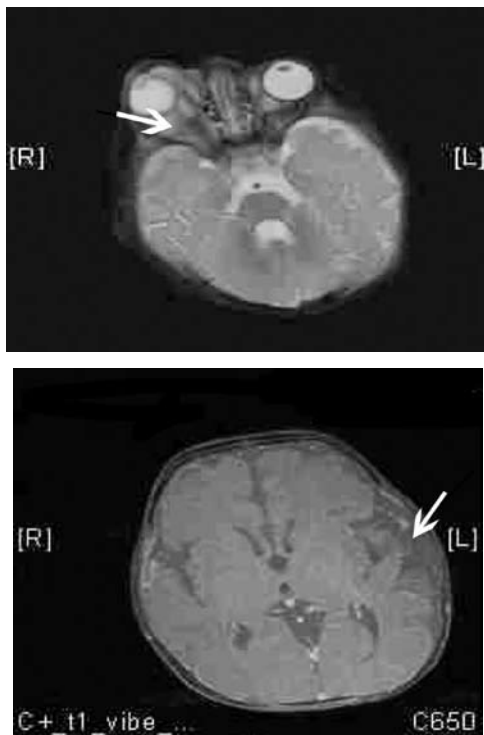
Magnetic resonance imaging showing the a) right orbital abscess with extension through eroded bone into the b) left temporal fossa (extradural collection) (patient 3).
